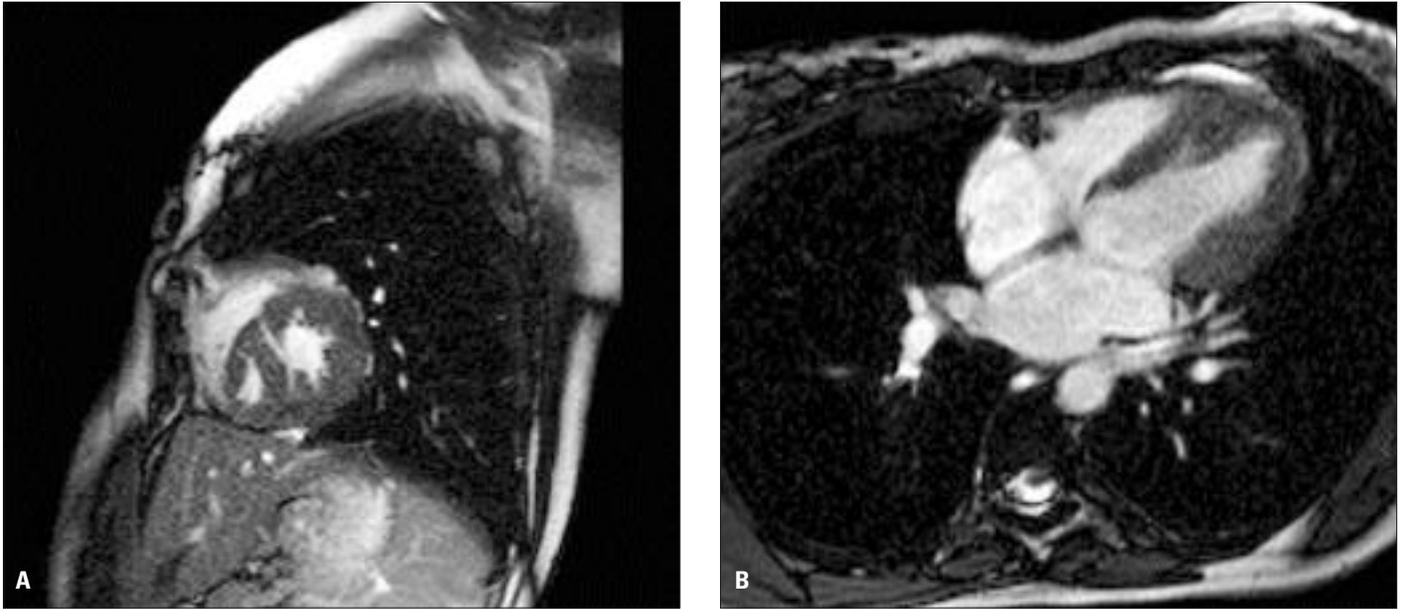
Systolic phase dynamic MR images in sagittal (A) and axial (B) views show the diverticulum itself with active systolic contraction. (MR: magnetic resonance)
